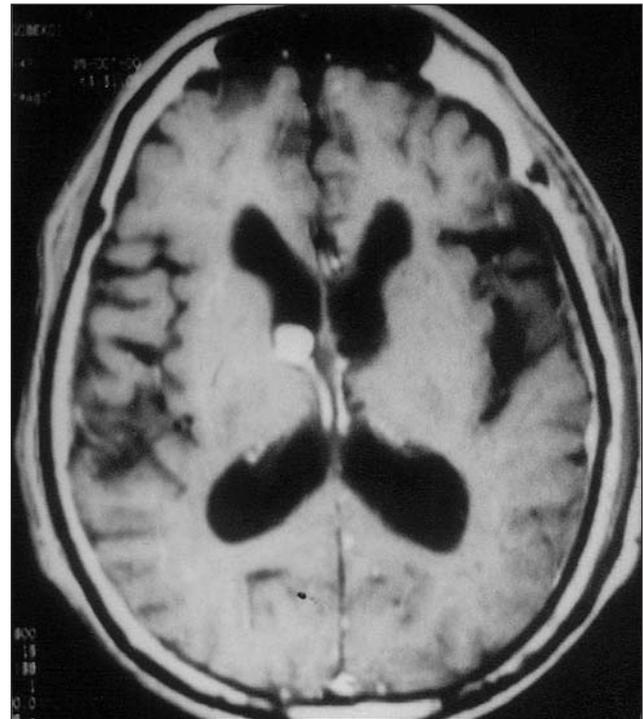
The axial MRI scan of the patient showing a contrast-enhancing mass lesion in the right lateral ventricle.
